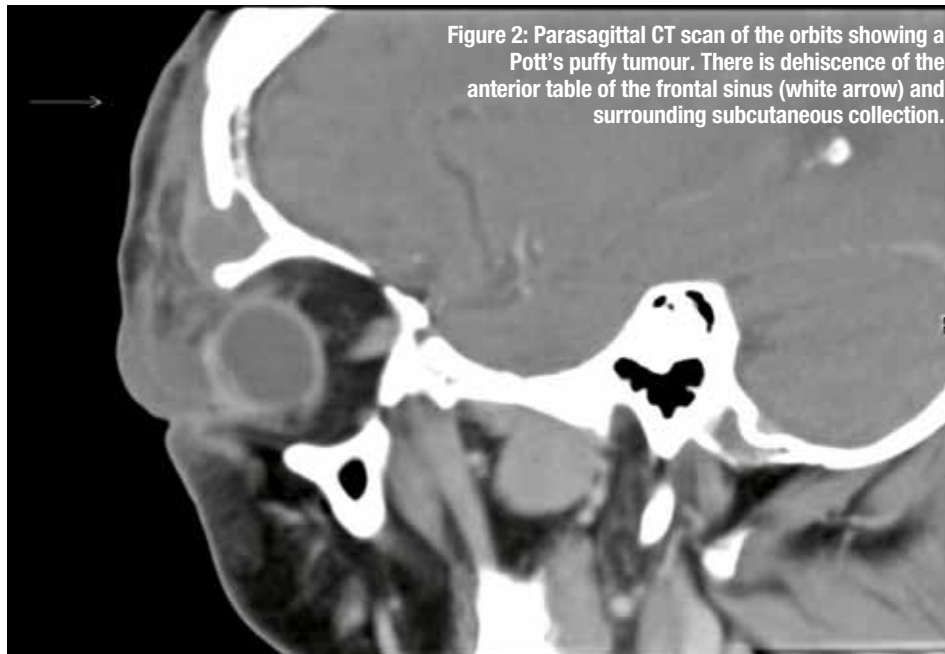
Parasagittal CT scan of the orbits showing a Pott's puffy tumour. There is dehiscence of the anterior table of the frontal sinus (white arrow) and surrounding subcutaneous collection.
